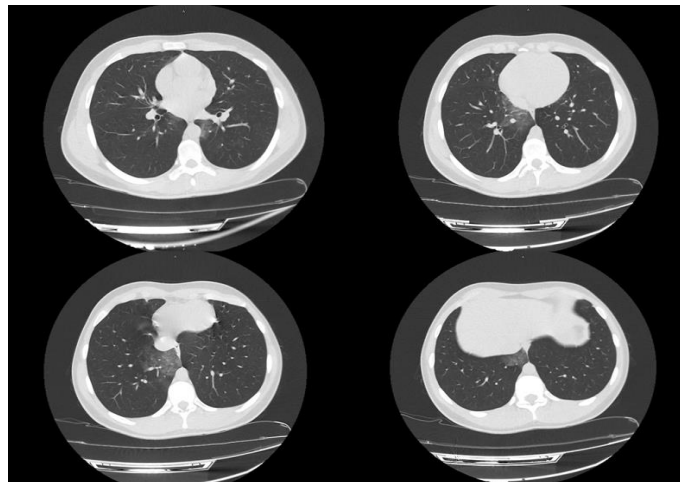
Thorax CT imaging sections, focal ground-glass density increases were observed in the parahilar region at the level of the right lung middle lobe, and in the parahilar region of the left lung lower lobe superior segment
